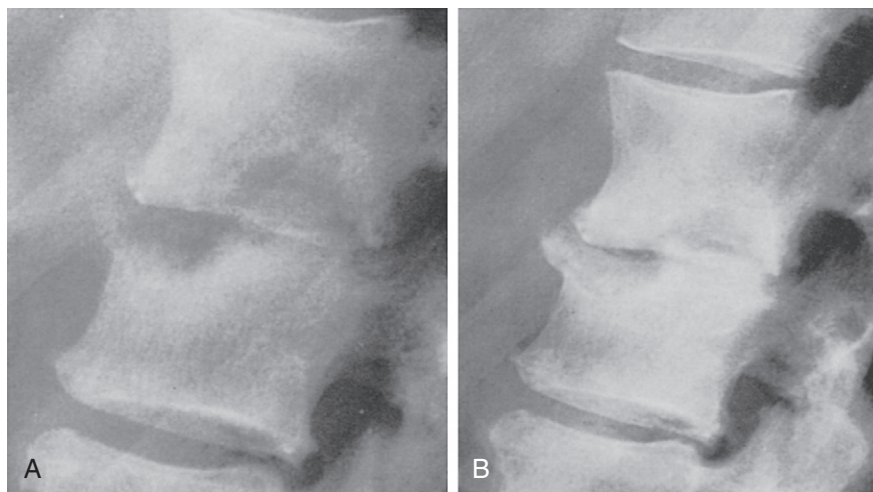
Tuberculous spondylitis with discovertebral lesion. A, The initial radiograph reveals subchondral destruction of two vertebral bodies, with mild surrounding eburnation and loss of intervertebral disk height. The appearance is identical to that in pyogenic spondylitis. B, Several months later, an osseous response is evident. Note the increased sclerosis. Osteophytosis and improved definition of the osseous margins can be seen. (From Resnick D: *Diagnosis of bone and joint disorders*, ed 3, Philadelphia, 1995, WB Saunders, p 2465.)
